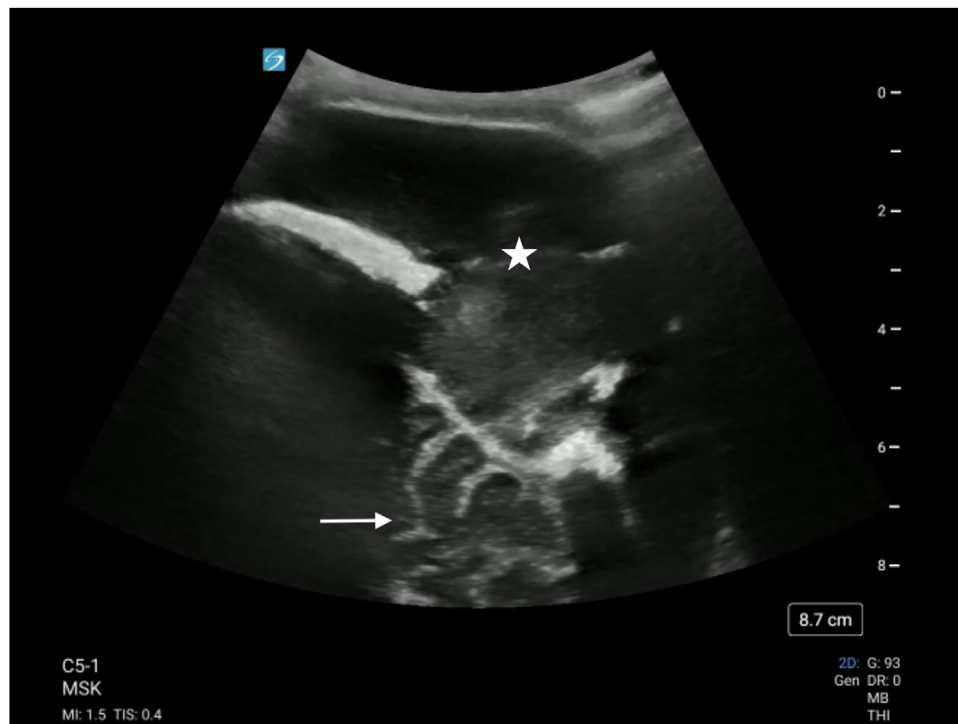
Ultrasound image soft-tissue mass on scalp (*) and brain gyri (arrow). normal-appearing skin on the right parietal scalp, partially obscured by
